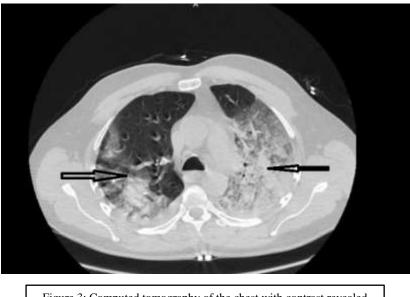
Computed tomography of the chest with contrast revealed bilateral patchy ground-glass interstitial infiltrates (arrow)
